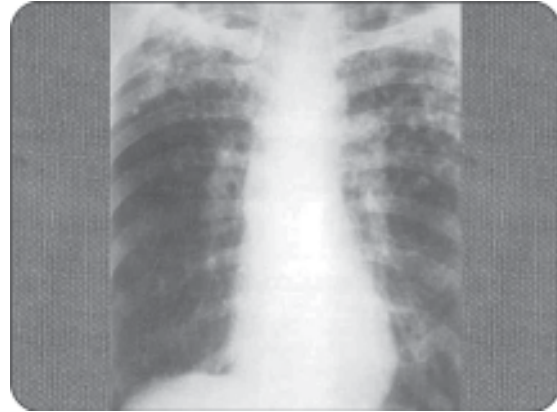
X-ray shows prominent hilar lymph nodes in a tuberculosis patient
